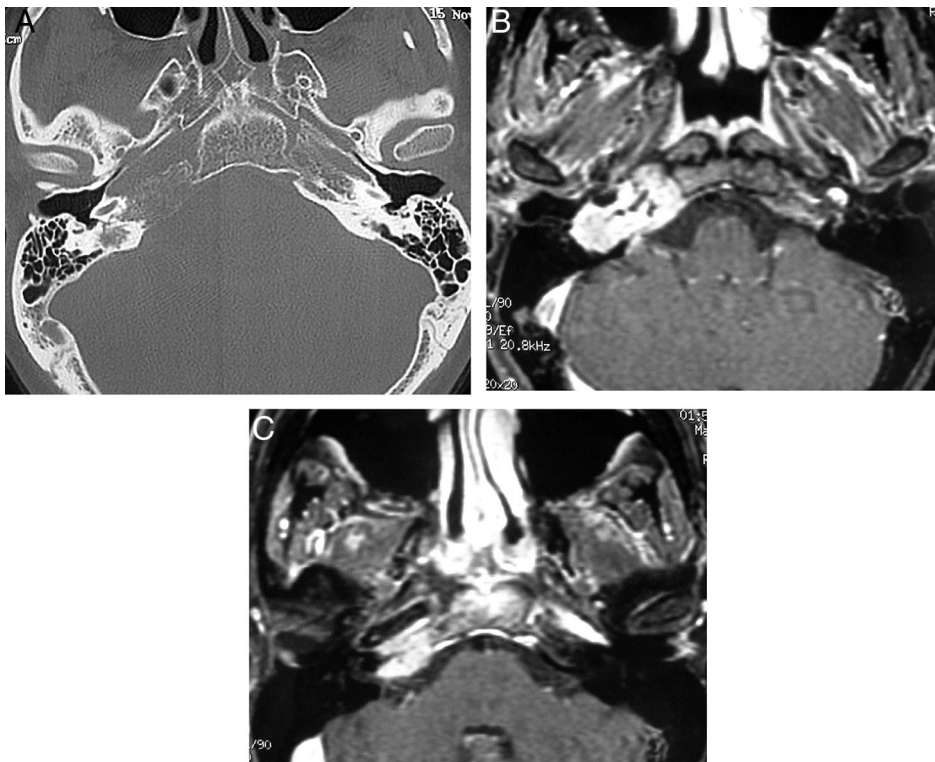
High-resolution computed tomography scans showing bone erosion of the horizontal segment of the right internal carotid artery (ICA). (A) Gd-enhanced fat-suppressed magnetic resonance imaging showing tumor encasement of the vertical segment (B) extending along the horizontal segment (C) of the right petrous ICA. Occlusion of the left petrous ICA can be appreciated.
